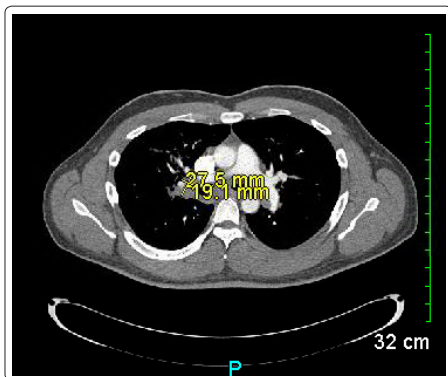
CT of Chest without Contrast
